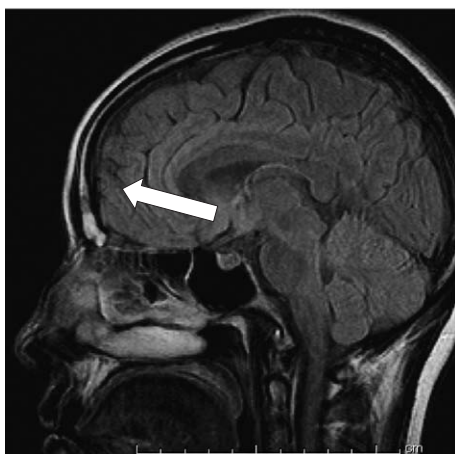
T1-weighted MRI obtained on May 9 showed that there was no longer any abscess in the left frontal tip (white arrow).
